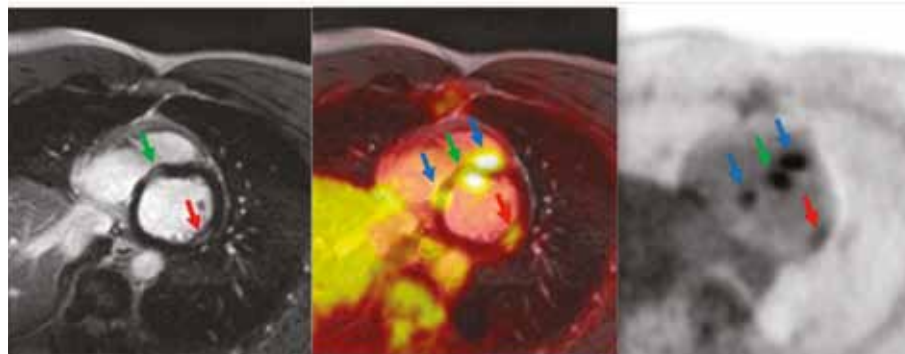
FDG PET/MRI of a patient with active cardiac sarcoidosis.
